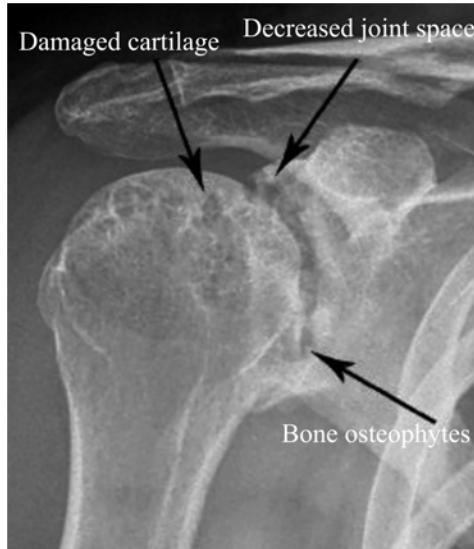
X-ray of an arthritic shoulder: the damaged cartilage induces a decrease in the joint space and osteophytes can generate (Figure adapted from [5]).
